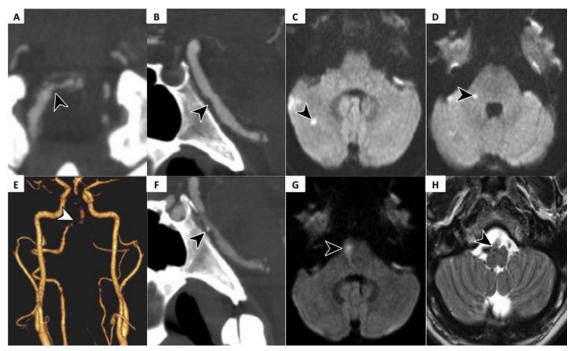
Neuroimaging of late-onset Pompe disease. CTA depicting (A) right vertebral dissection in axial view with a beaded appearance of vasculature at the vertebrobasilar junction, and (B) mid-basilar stenosis in sagittal view. (C and D) Diffusion-weighted MRI showing punctate infarcts in the right cerebellar and middle cerebral peduncle. Eight months later, the patient presents with left brachiocrural hemiparesis. (E and F) CTA demonstrates progression of stenosis of the vertebrobasilar junction with severe stenosis at mid-basilar segment. (G) MRI brain diffusion-weighted MRI sequence showing right paramedian pontine infarction, and (H) T2-weighted sequence showing right dolichoectatic vertebral artery compressing right pontine hemisphere. Abbreviations: CTA, computed tomographic angiography; MRI, magnetic resonance imaging.
